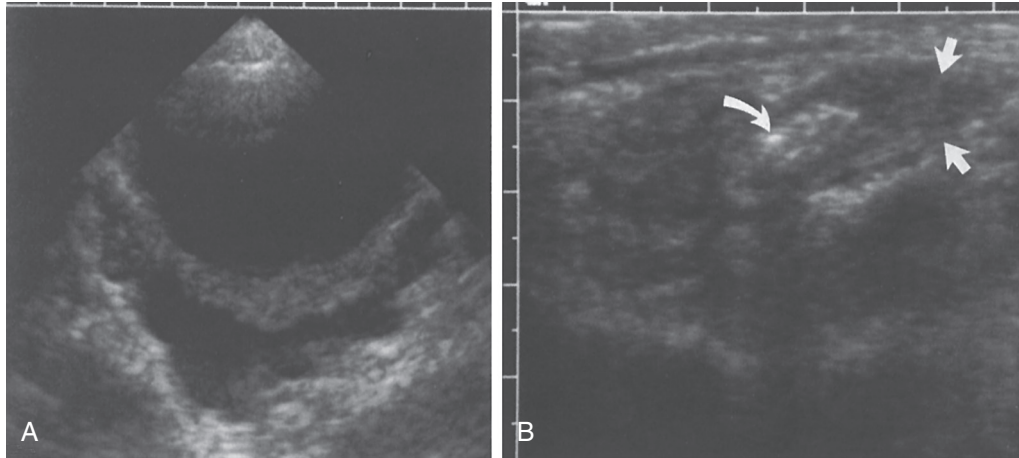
A transverse scan of the pelvis shows free fluid pooling behind the bladder (A). The longitudinal scan of the right lower quadrant (B) shows a shadowing appendicolith (*curved arrow*) in a thick-walled appendix, typical of appendicitis. *Straight arrows* outline the appendiceal tip, which looks ready to perforate. Free fluid in the pelvis always increases the suspicion of appendicitis. (From Teele R, Share J. Appendicitis and other causes of intraabdominal inflammation. In: *Ultrasonography of Infants and Children*. Philadelphia: WB Saunders; 1991:349.)
